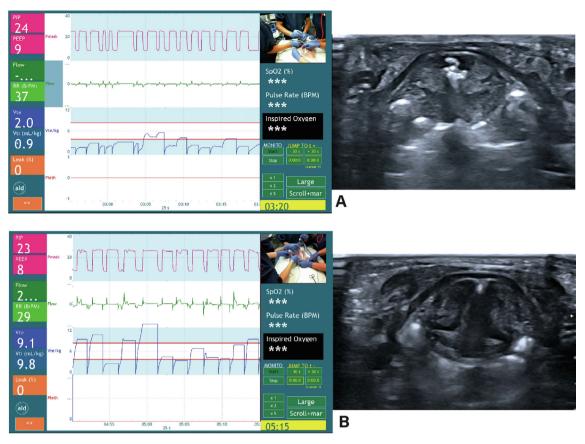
RFM synchronised with ultrasonography of vocal cords. Vital parameters depicted by the RFM include positive end-expiratory pressure and peak inspiratory pressure (pink), flow and respiratory rate (green), expired tidal volume (blue) and mask leak (orange), oxygenation, heart rate, and fraction of inspired oxygen. A. iPPV inflations are given to an infant of 25 + 4 weeks with closed vocal cords. B. iPPV inflations are given to an infant of 27 + 6 weeks with vocal cords that opened at irregular times during the inflations.
